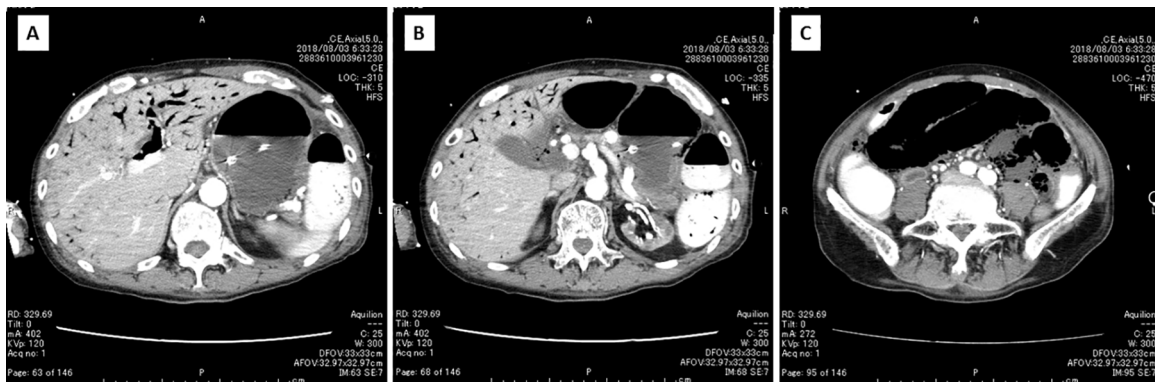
Non-occlusive mesenteric ischemia detected by contrast-enhanced multidetector computed tomography. These images are shown from head side to foot side (Panel A–C). Angiographic phase did not show an occlusion in superior mesenteric artery and showed impaired filling of intramural vessels and mural thinning (paper-thin wall of intestine) (Panel B). Pneumatosis intestinalis in a large segment of small bowel and hepatic portal venous gas were revealed (Panel A and C).
